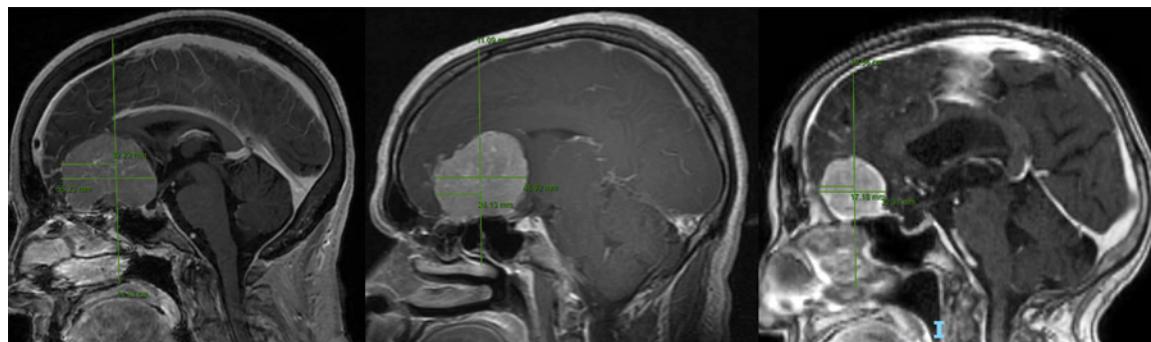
Representative sagittal contrast-enhanced T1-weighted MR images obtained in 3 patients with OGMs included in this study based on > 25% of the anteroposterior tumor diameter overlying the cribriform plate and anterior to the insertion of the sphenoid sinus. Figure is available in color online only.
